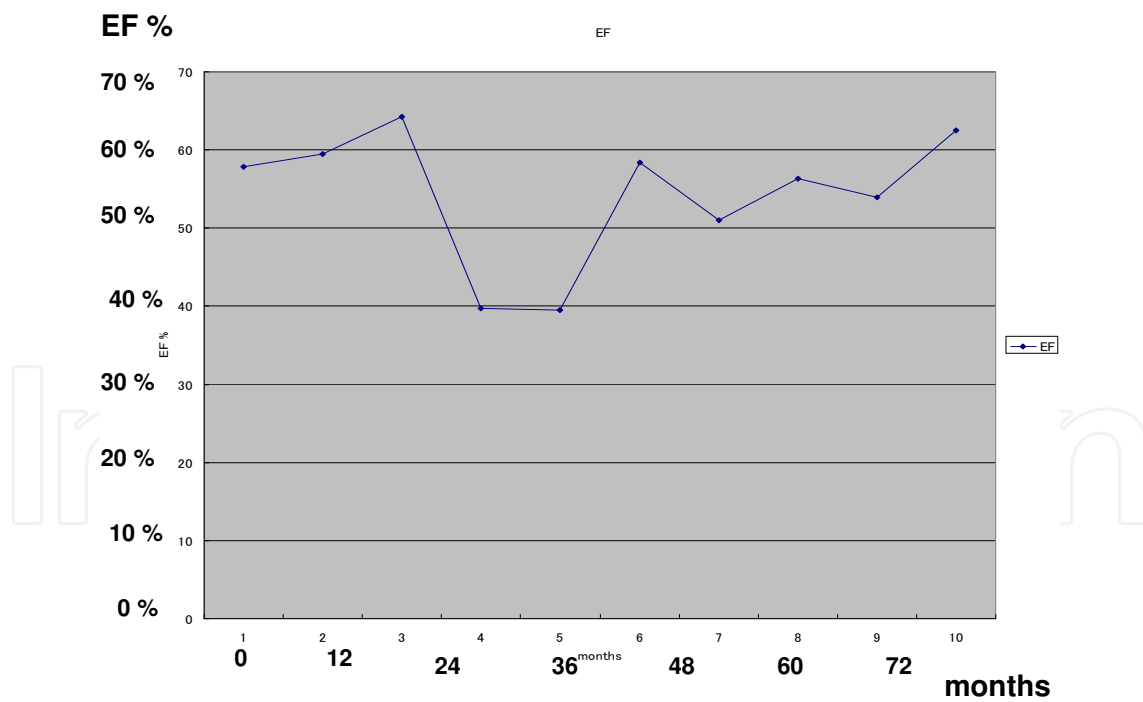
Longitudinal course of the ejection fraction on UCG 62-year-old female, nonsmoker, BHL, lung, ACE 29.0, heart with complete AV block Ordinate: ejection fraction (%) on echocardiography Abscissa: months from the introduction of therapy
